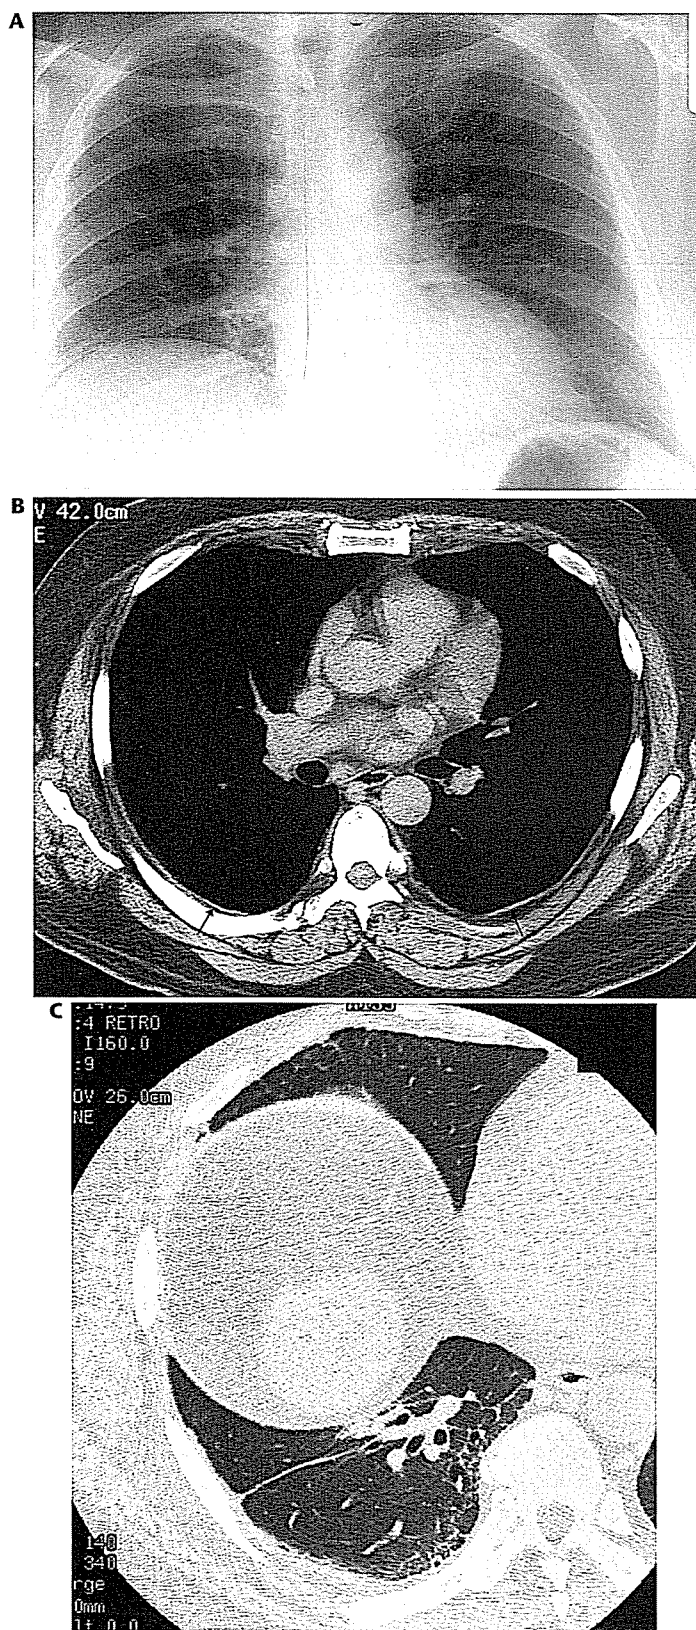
A 60-year-old male with radiographically occult pleural plaques and asbestosis. A, Chest radiograph is normal apart from elevated right hemidiaphragm and mild cardiomegaly. B, CT shows pleural plaques (arrows) which are not visible on the chest radiograph because they are posterior. C, Supine HRCT shows fine parenchymal reticular abnormality with traction bronchiectasis. Septal thickening is seen in the nondependent anterior right lung.
